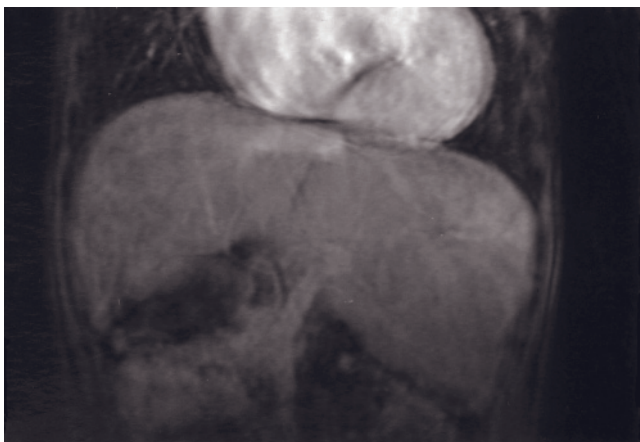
(Continued) immediate postgadolinium T1-weighted SGE (f), and delayed postgadolinium fat-suppressed T1-weighted SGE (g) images demonstrate the wandering spleen located in the pelvis in another patient.
